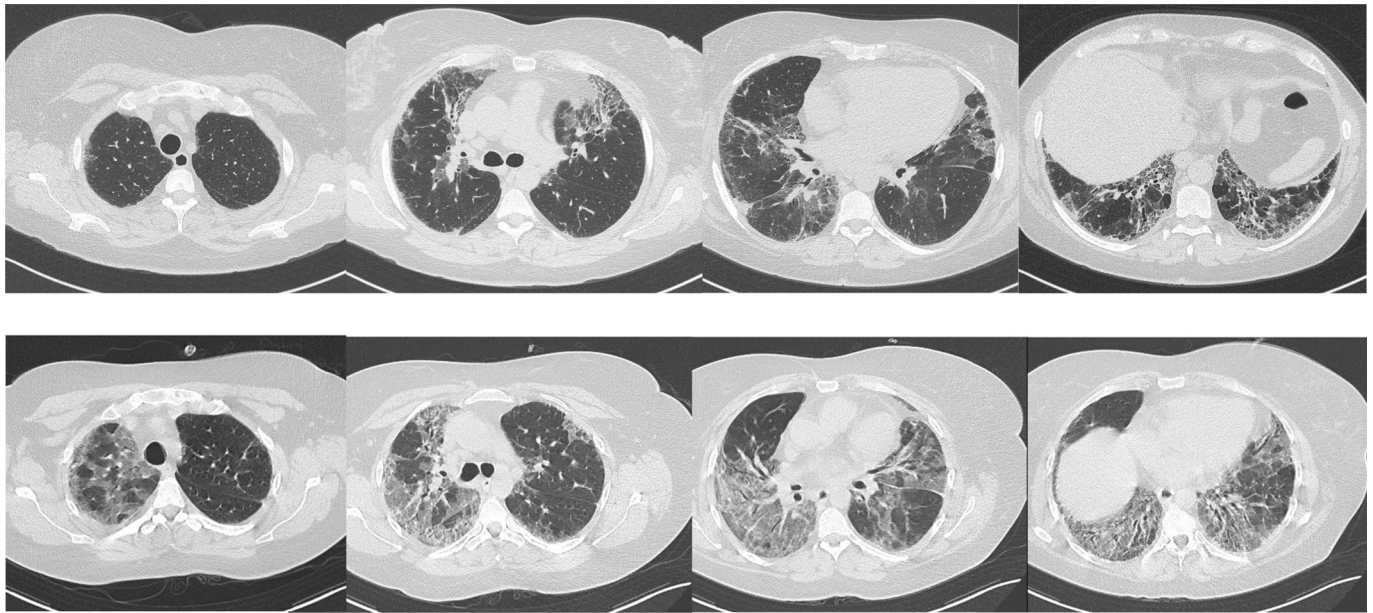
High resolution computed tomography of the chest in a patient with AE-ARD-ILD. Upper panel: basal subpleural reticulation, traction bronchiectasis, and honeycombing; lower panel: superimposed ground glass opacities are visible, with architectural distortion.
